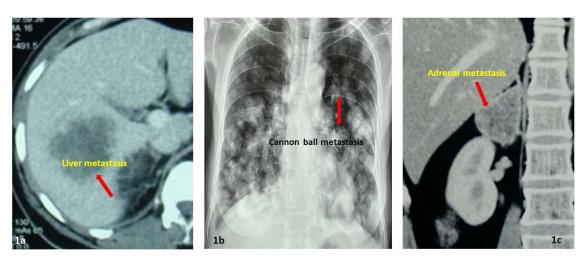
1a) CT showing hypodense lesions suggestive of metastasis from RCC. 1b) Multiple discrete lesions over bilateral lung fields suggestive of metastatic lesion (cannon ball). 1c) CT showing hypodense lesion over the Rt. adrenal gland suggestive of metastasis
